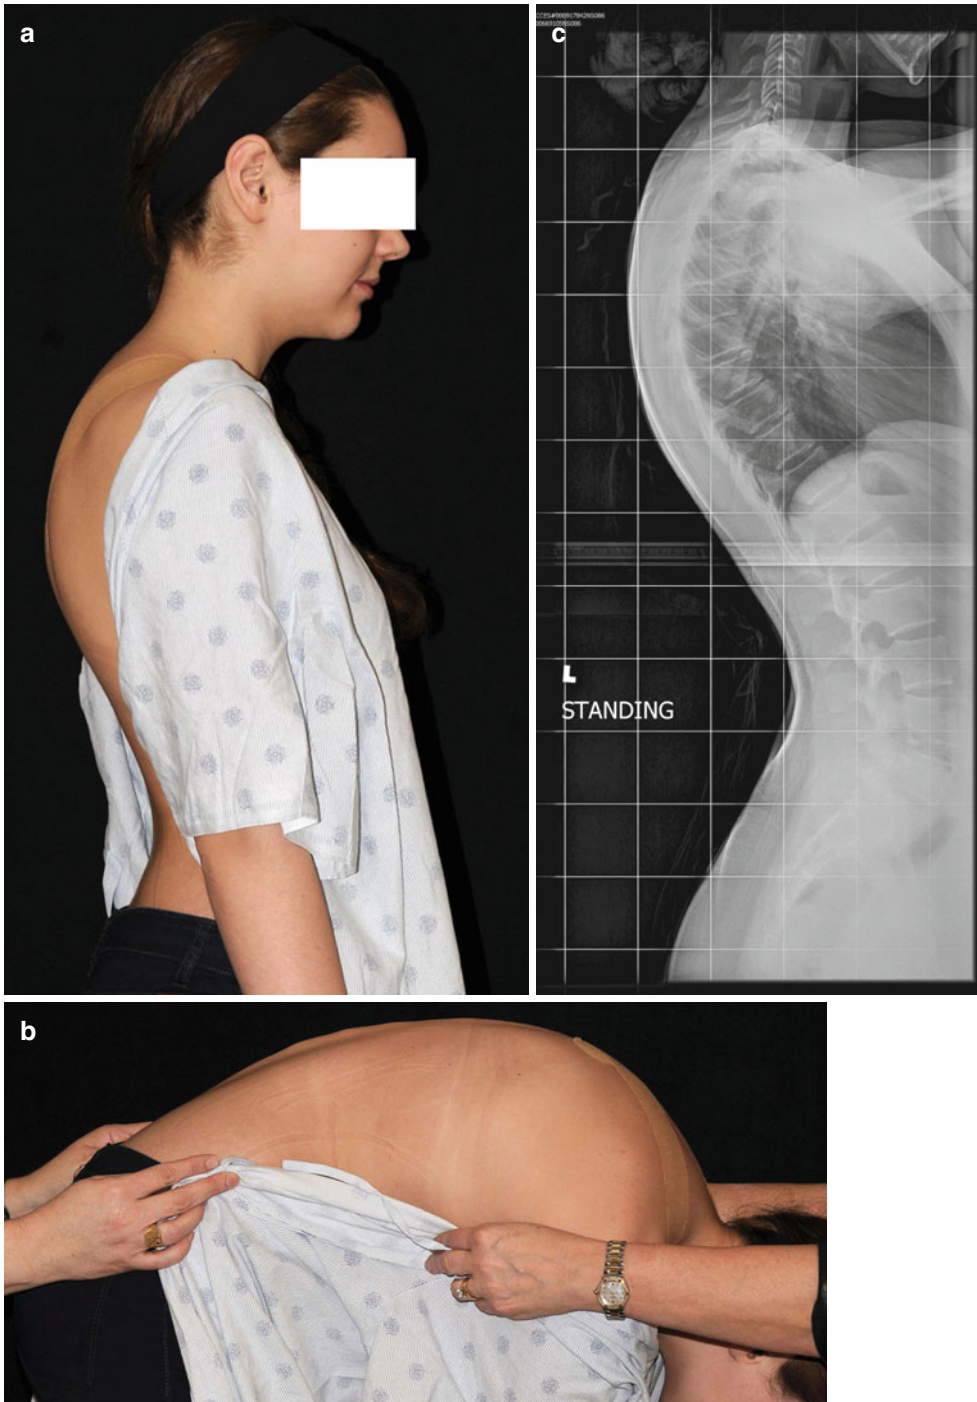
A 13-year-old girl with hyperkyphosis. (a) Clinical photograph. (b) Clinical photograph with forward bending demonstrating loss of hyperkyphosis. (c) Standing lateral radiograph demonstrating T5–T12
